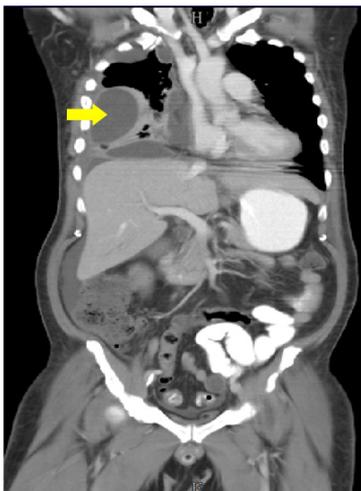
CT scan of thorax showed loculated right pleural effusion with pleura enhancement suggestive of empyema thoracis (yellow arrow). Right lower lobe was completely collapsed. Areas of aerated right upper lobe and middle lobe were seen in between the locules.
